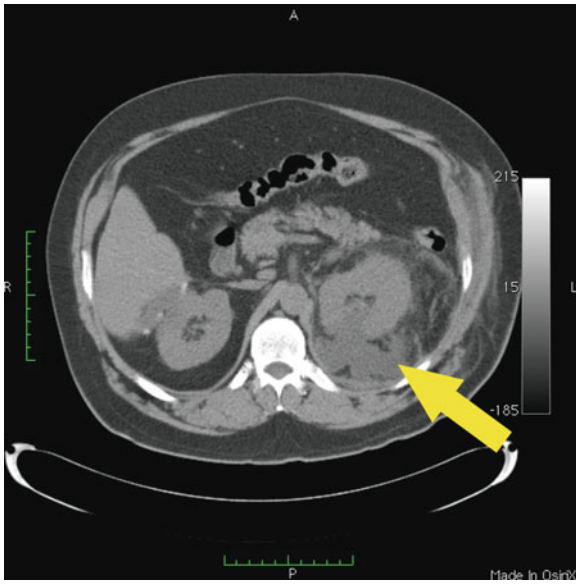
A urinoma on the left side demonstrated in CT scan
